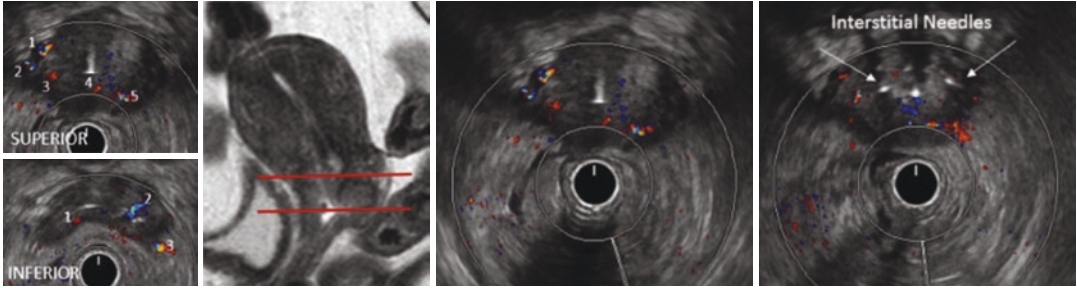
Vessel size and distribution on Doppler USG
